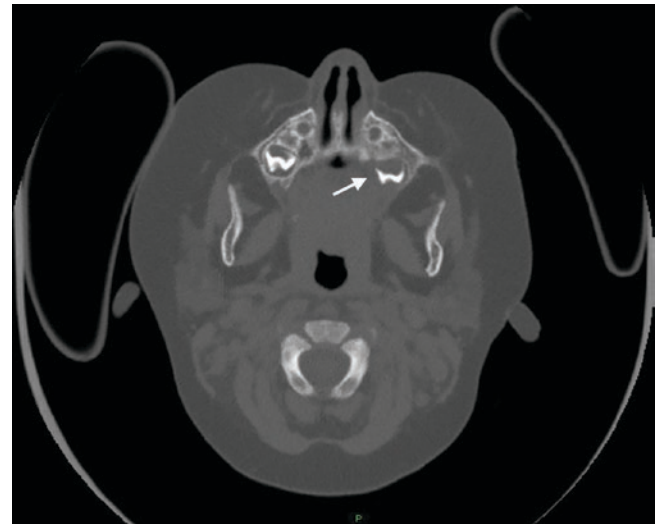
“Floating tooth” appearance in association with LCH. Axial CT image demonstrates the loss of alveolar bone around an upper left deciduous molar tooth (*arrow*)
